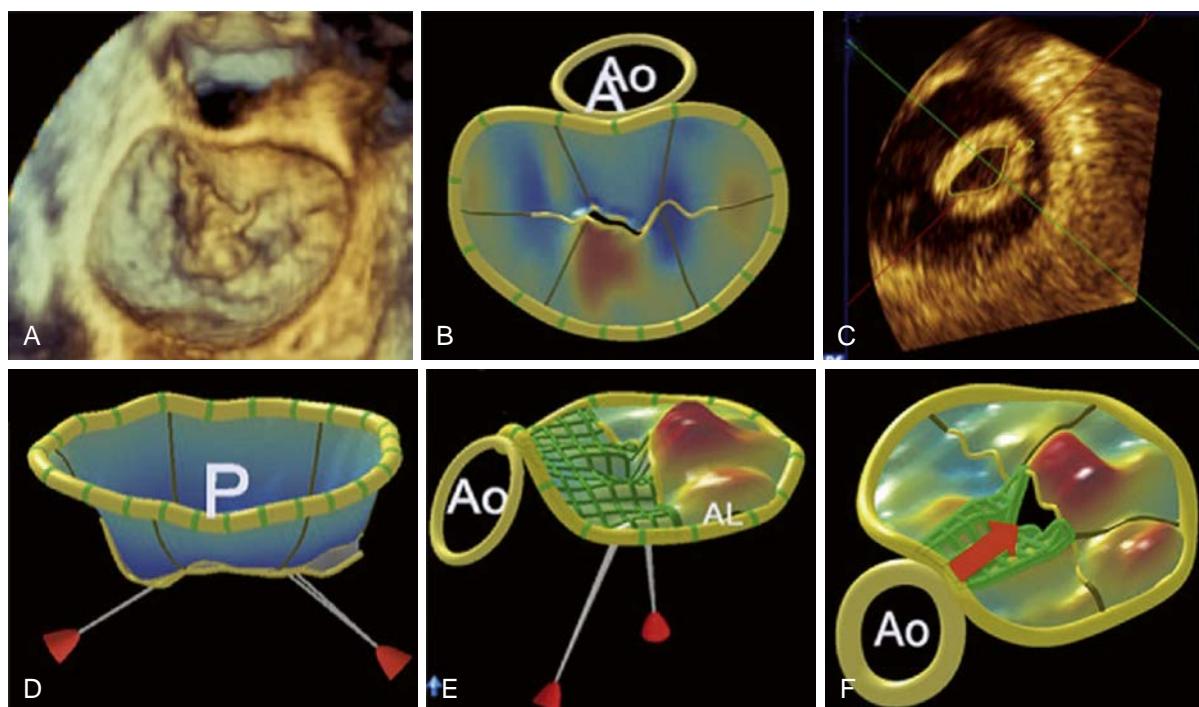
The components of the mitral valve leaflets using three-dimensional echocardiography. *A*, Atrial aspect of the Mitral valve. Prolapsing P2 scallop can be seen. *B*, 3D reconstruction of the Mitral valve showing P2 scallop in red. *C*, Ventricular aspect of the Mitral valve. *D*, Side view of the 3D reconstruction of the Mitral valve with the chordae in view. *E*, View from the anterolateral commissure of the Mitral valve, with prolapsing scallop in red. *F*, Atrial view of the valve showing prolapsing scallops and the failure of coaptation of leaflets causing the regurgitant jet.
